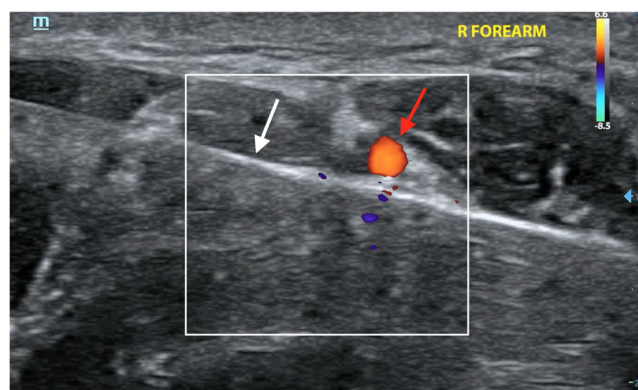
Ultrasonographic image of the nail penetrating just adjacent to the ulnar artery
